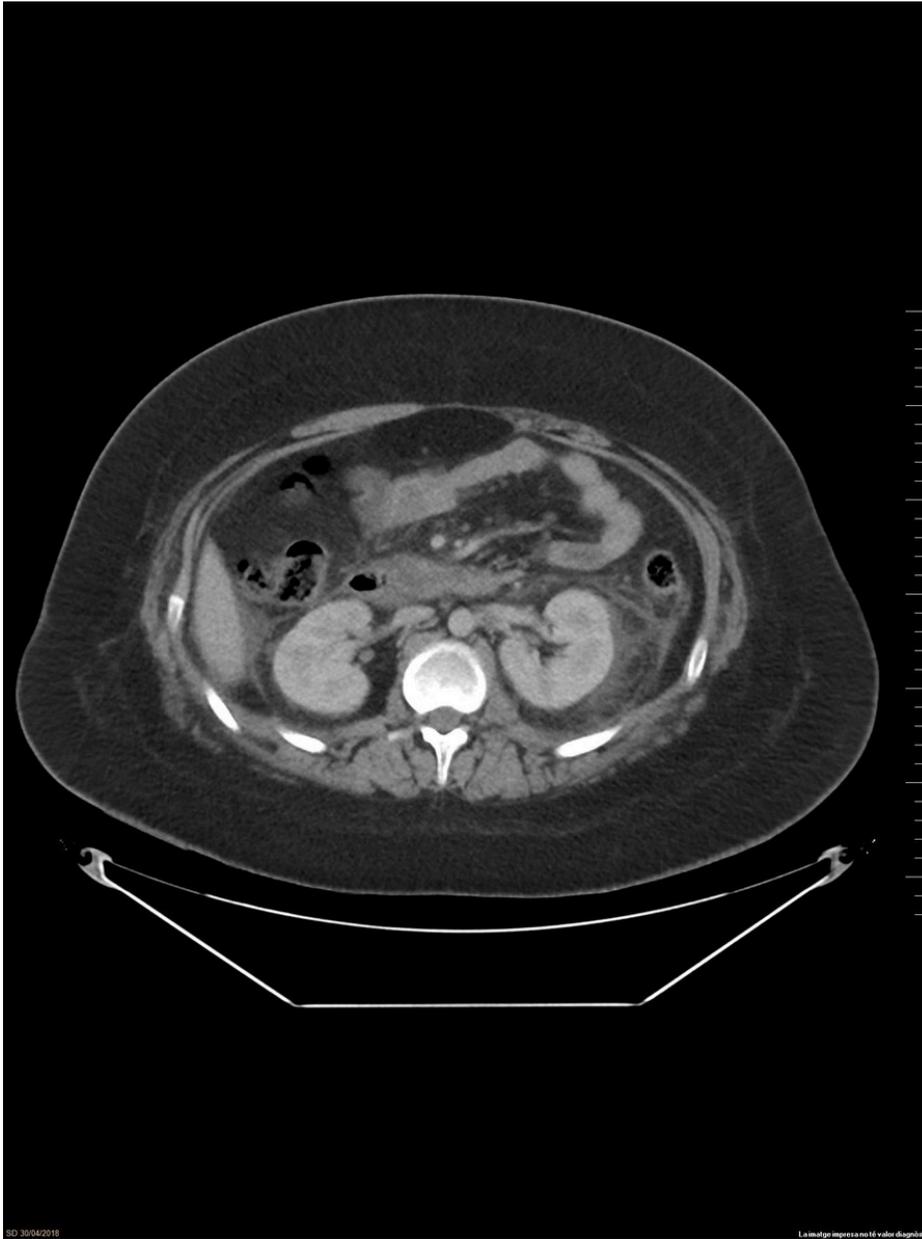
Homogeneous pancreatic enhancement in CT scan.
